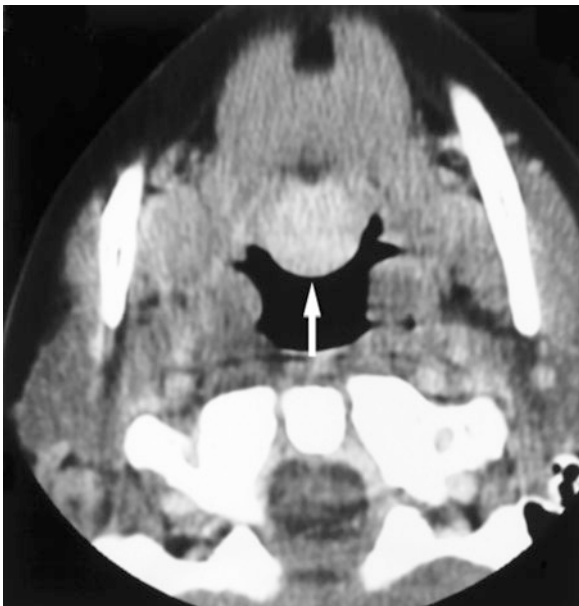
Lingual thyroid gland; 16-year-old female with lump in tongue base. Axial post-contrast CT shows soft-tissue mass in posterior part of tongue (*arrow*)
